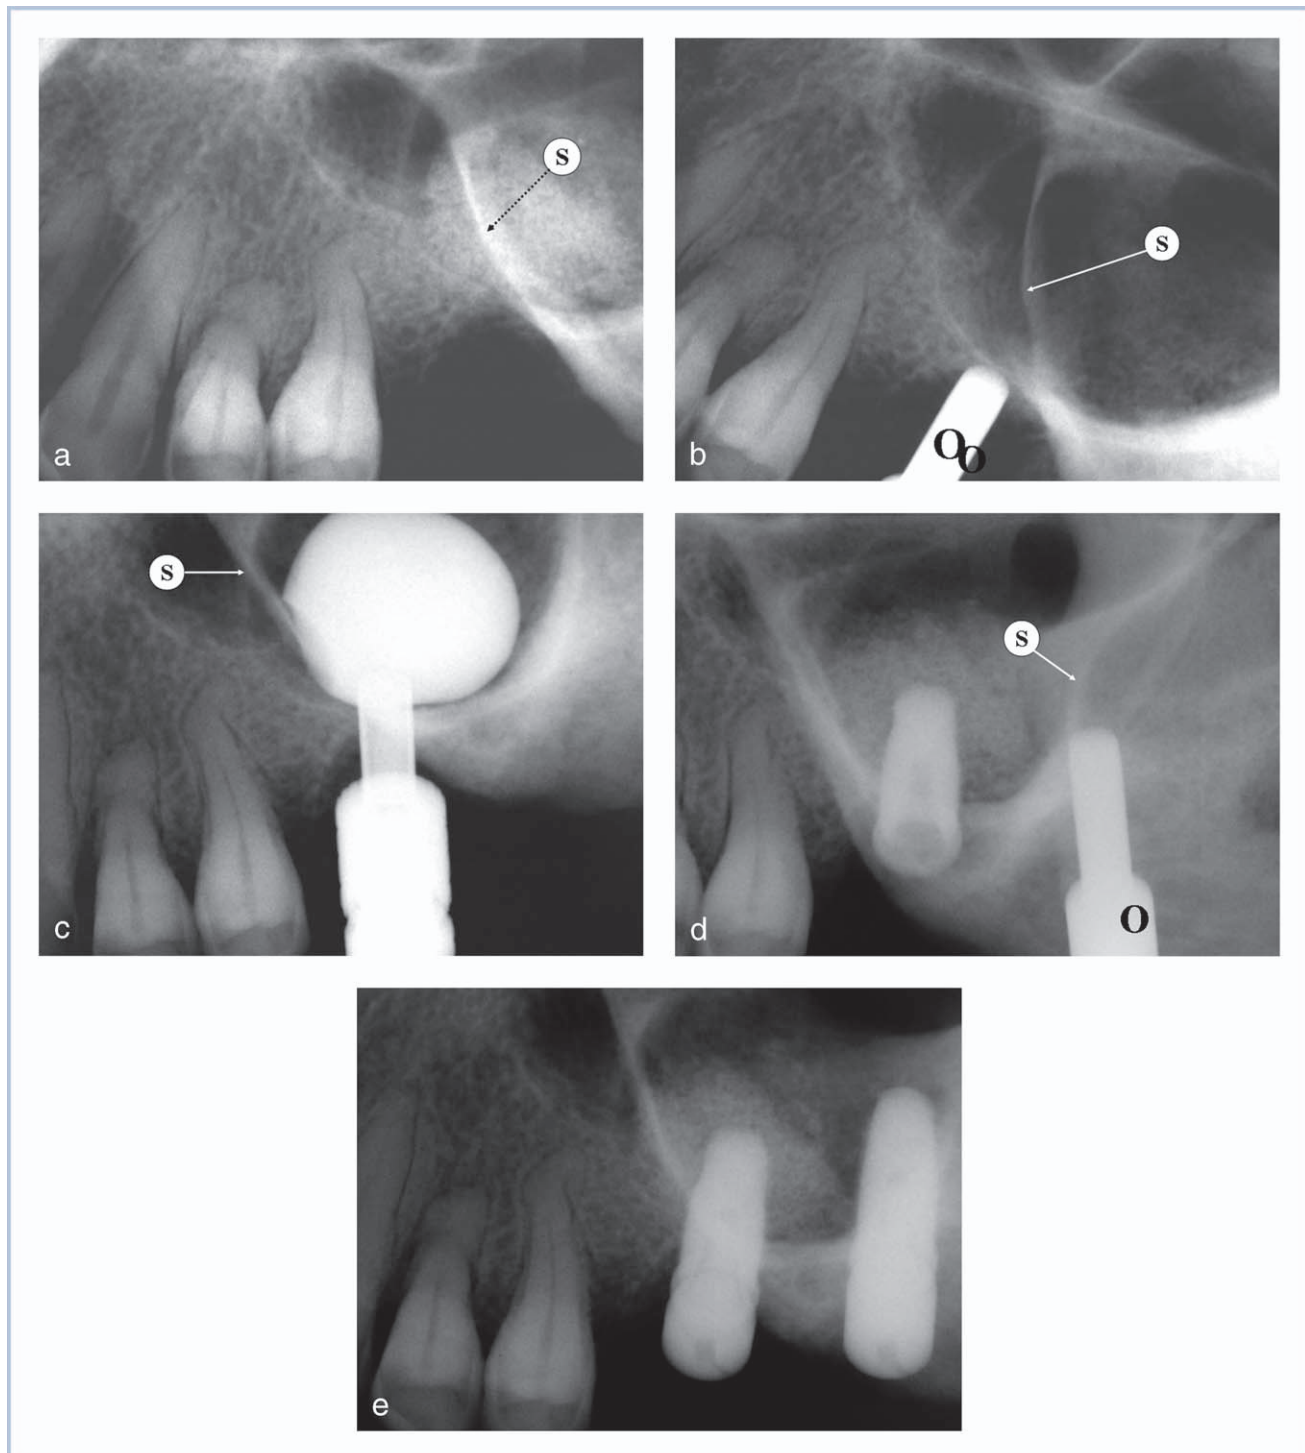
Case 2. (a) Preprocedural periapical radiograph: septum (S) noted. (b) Osteotome (O) fracturing the sinus floor. (c) First balloon inflation (MIAMBE) of the anterior compartment. (d) After bone grafting of the anterior compartment and implant placement, osteotomy is enlarged toward the posterior compartment. (e) After MIAMBE and bone grafting of the posterior compartment implant placement.
